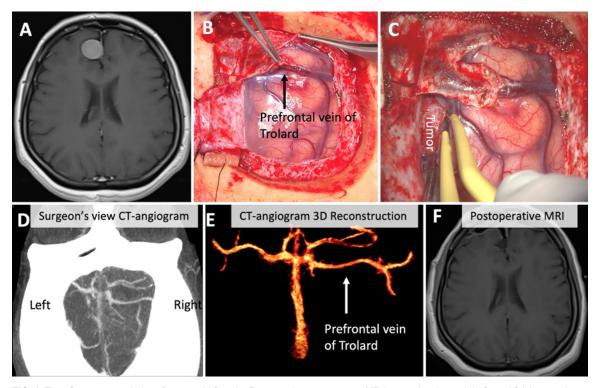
Type 2 case example in a 45-year-old female. Preoperative postcontrast MR image showing a right frontal falcine meningioma (A). A right frontal central craniotomy crossing the midline was performed to expose the SSS. Type 2 drainage is identified upon opening the dura, involving a prefrontal superior anastomotic vein of Trolard indirectly draining into the sinus by first coursing through the convexity dura anterior to the coronal suture (B). The dura is cut parallel to the 2 draining veins, and the underlying arachnoid tethering is dissected to better mobilize the veins anteriorly. An interhemispheric approach is then performed posterior to the veins for tumor resection (C). Preoperative CT angiogram (D) and 3D reconstruction (E) demonstrate this venous configuration. Postoperative postcontrast MR image shows gross-total resection (F).
